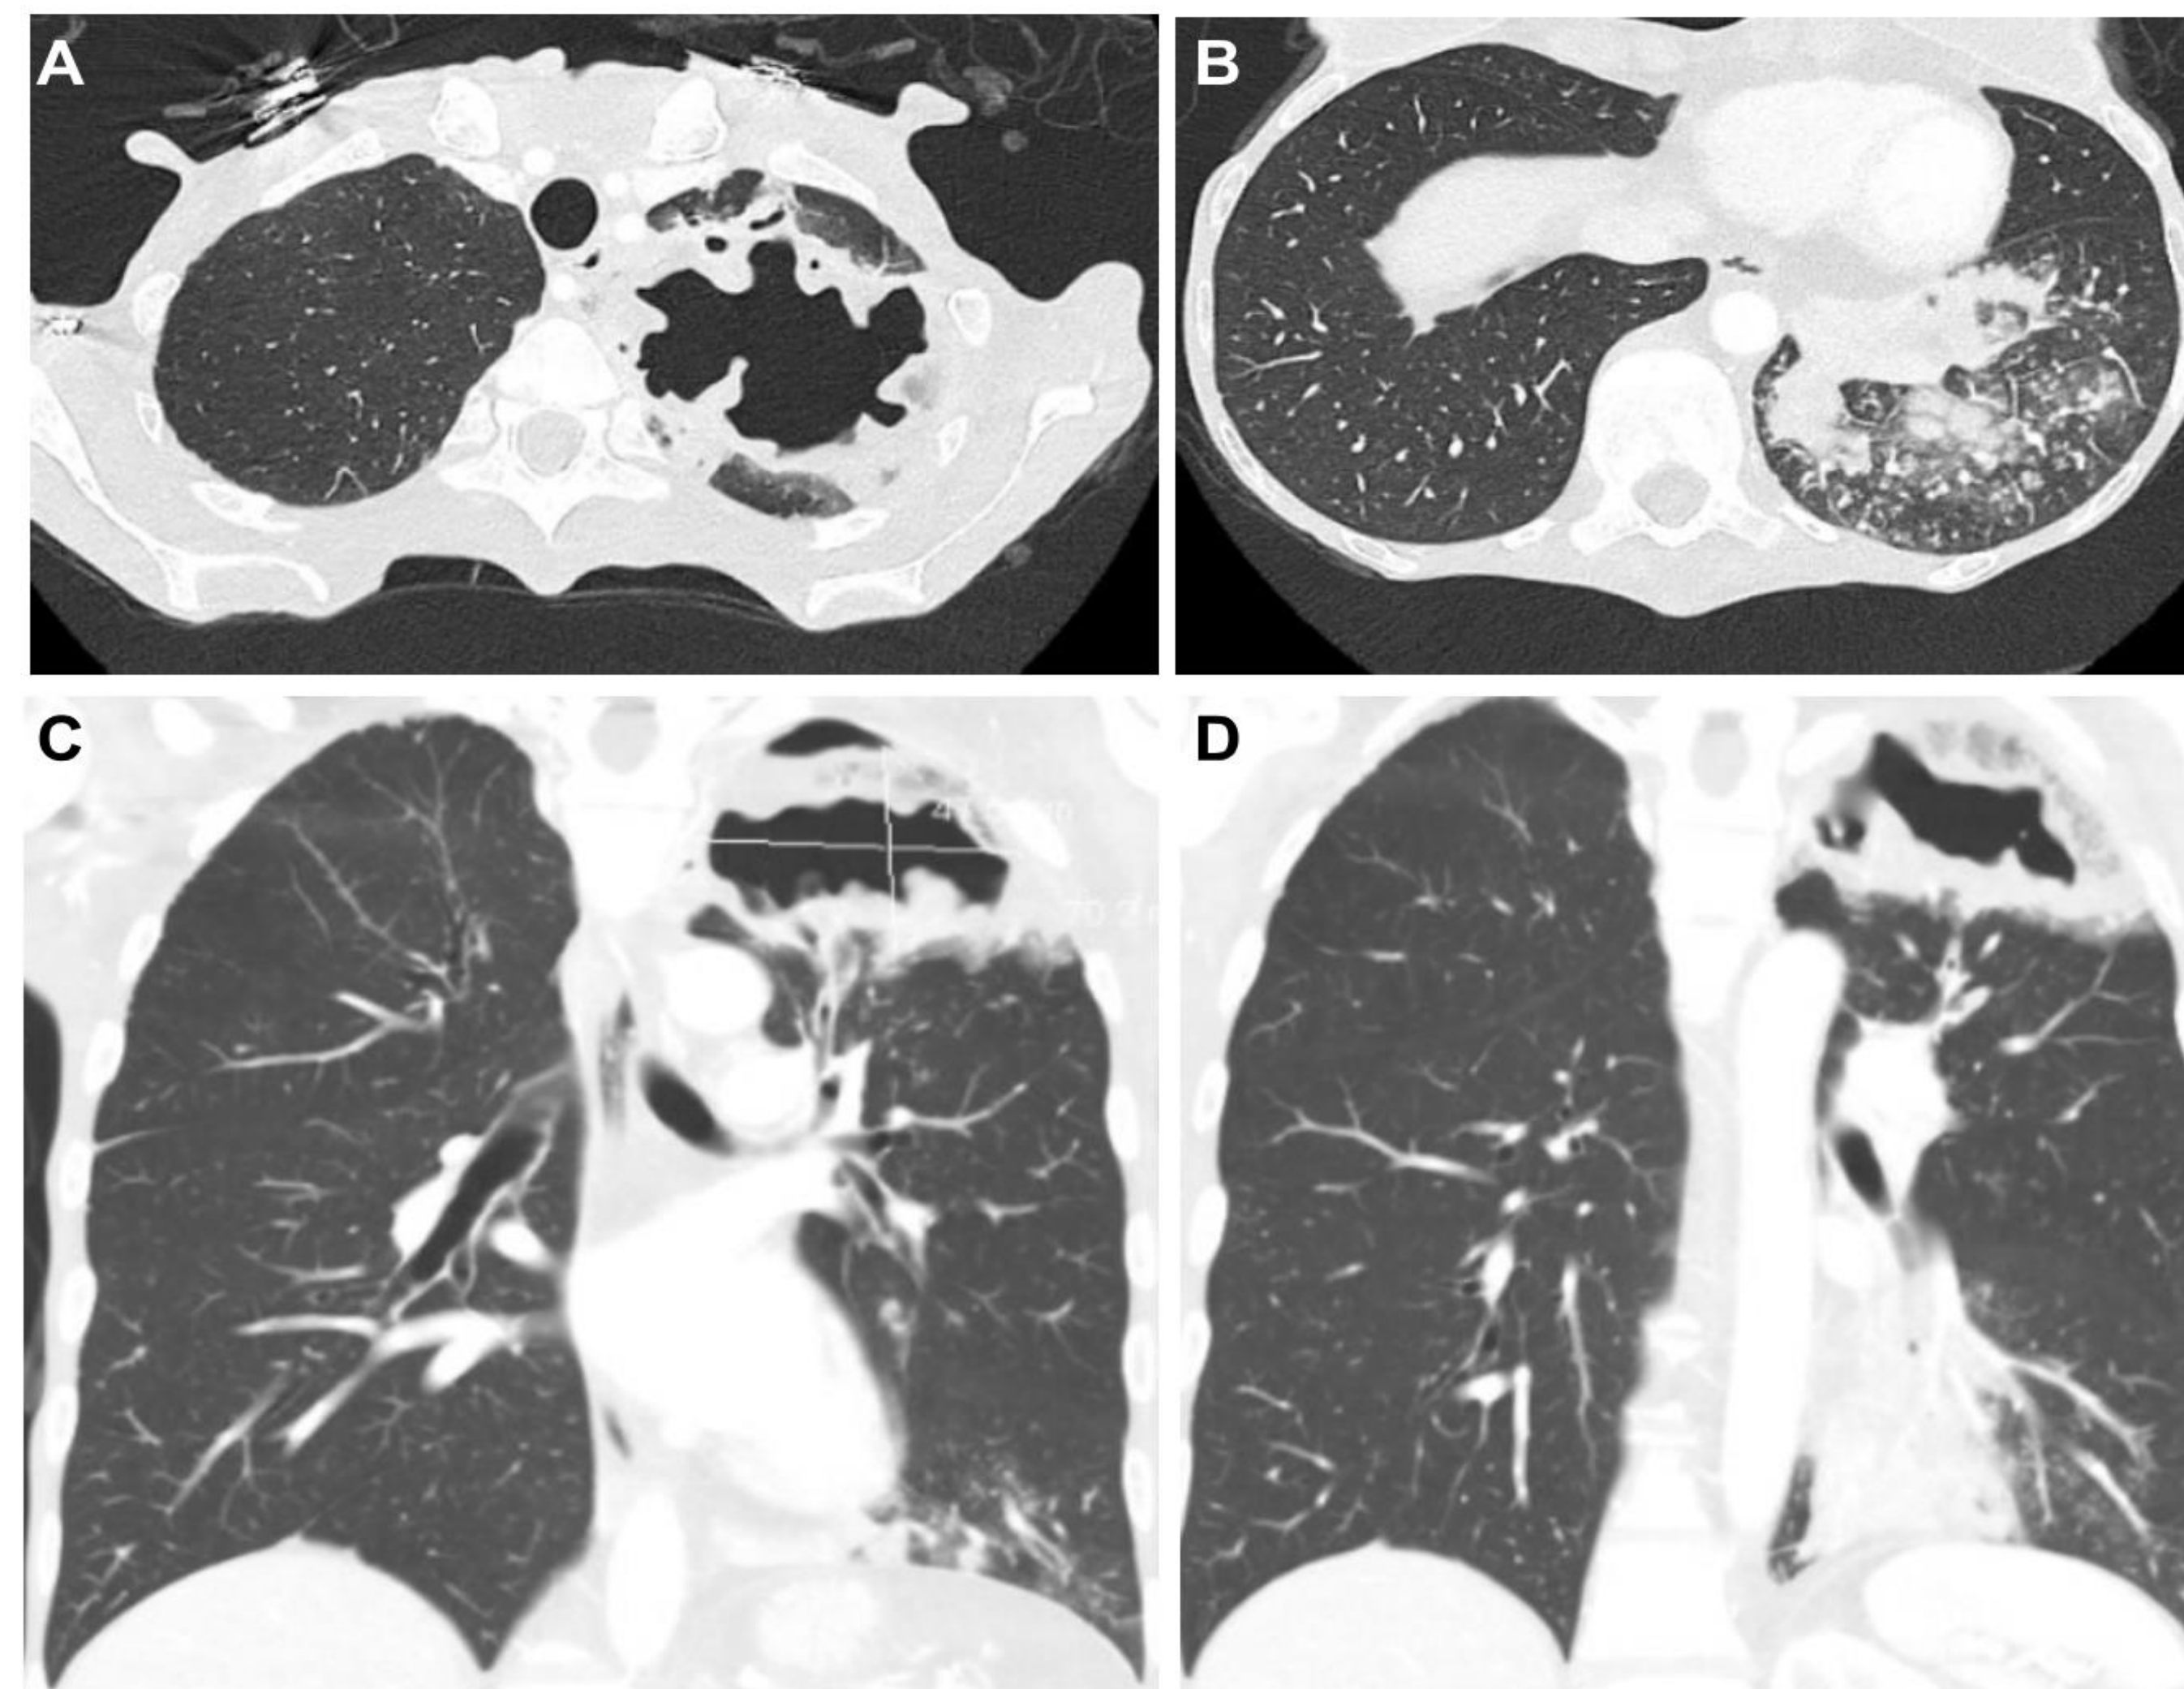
CT chest on index admission showing left apical cavitory lesion and left lower lobe reticulonodular infiltrates
